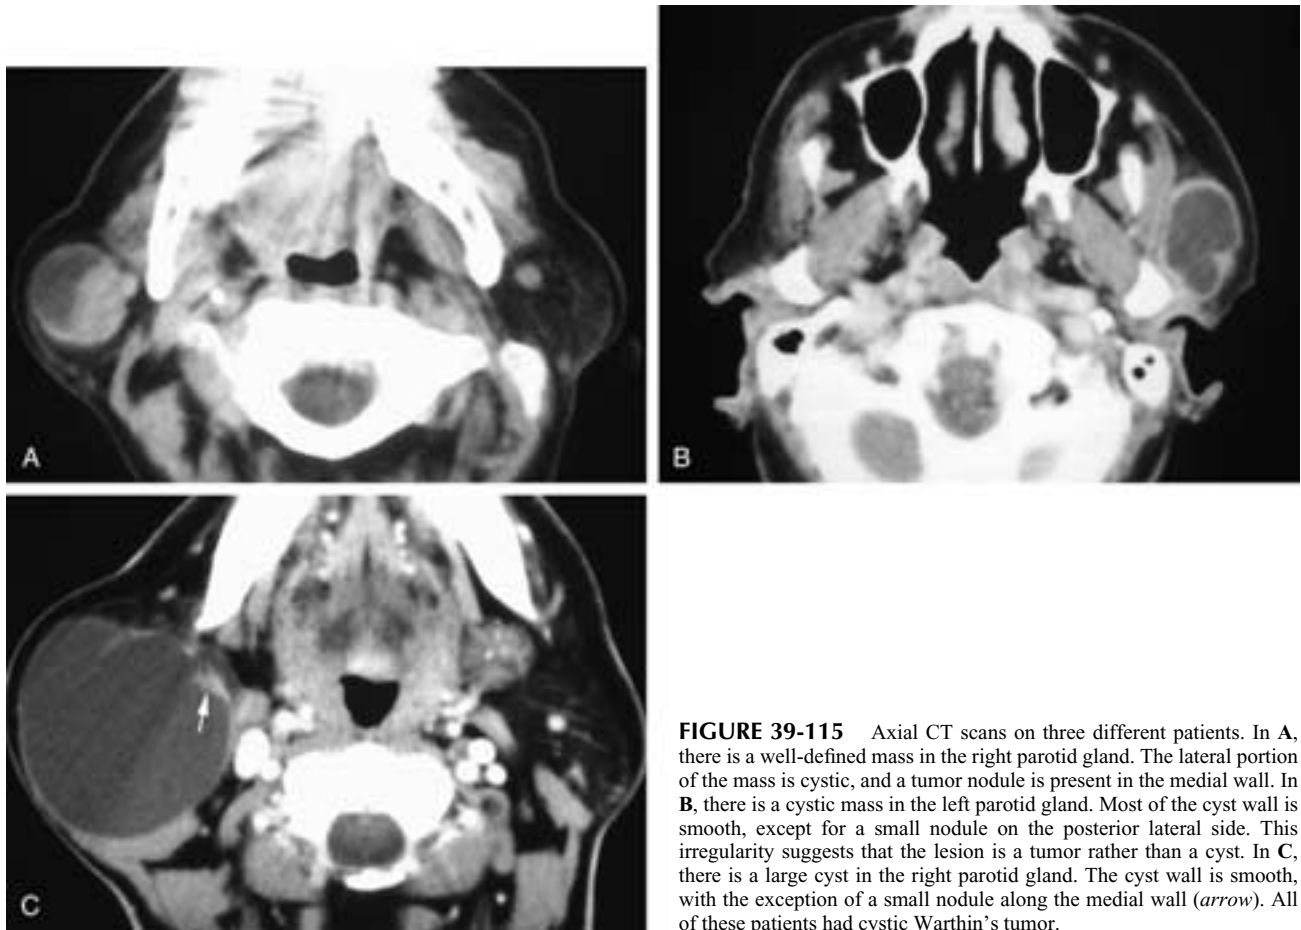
Axial CT scans on three different patients. In A, there is a well-defined mass in the right parotid gland. The lateral portion of the mass is cystic, and a tumor nodule is present in the medial wall. In B, there is a cystic mass in the left parotid gland. Most of the cyst wall is smooth, except for a small nodule on the posterior lateral side. This irregularity suggests that the lesion is a tumor rather than a cyst. In C, there is a large cyst in the right parotid gland. The cyst wall is smooth, with the exception of a small nodule along the medial wall (*arrow*). All of these patients had cystic Warthin's tumor.
